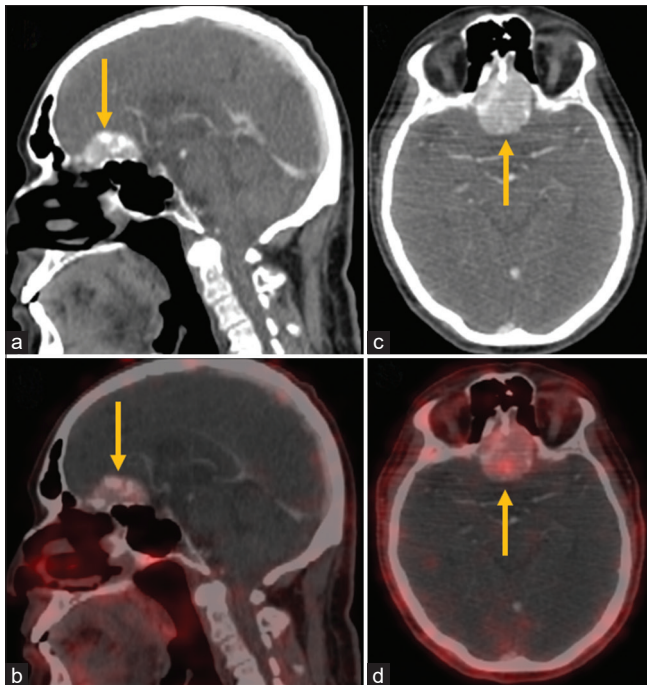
A 65-year-old male patient with adenocarcinoma prostate (Gleason score 4+4=8), serum PSA – 40 ng/ml, post TURP on androgen deprivation therapy was advised a 68Ga PSMA PET/CT scan which incidentally detected a well-defined enhancing dural based frontal lobe lesion with low grade tracer uptake (SUVmax 2.03) favouring meningioma (a-d; arrows)
